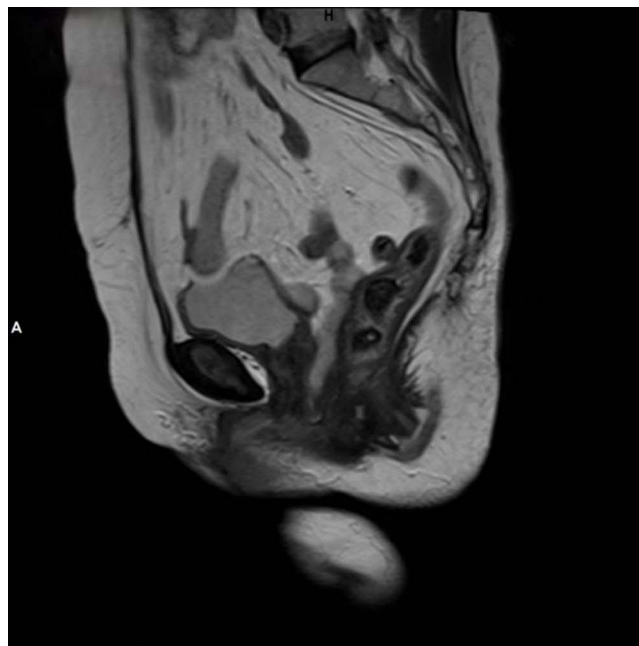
Magnetic resonance imaging revealed pelvic floor hernia.
